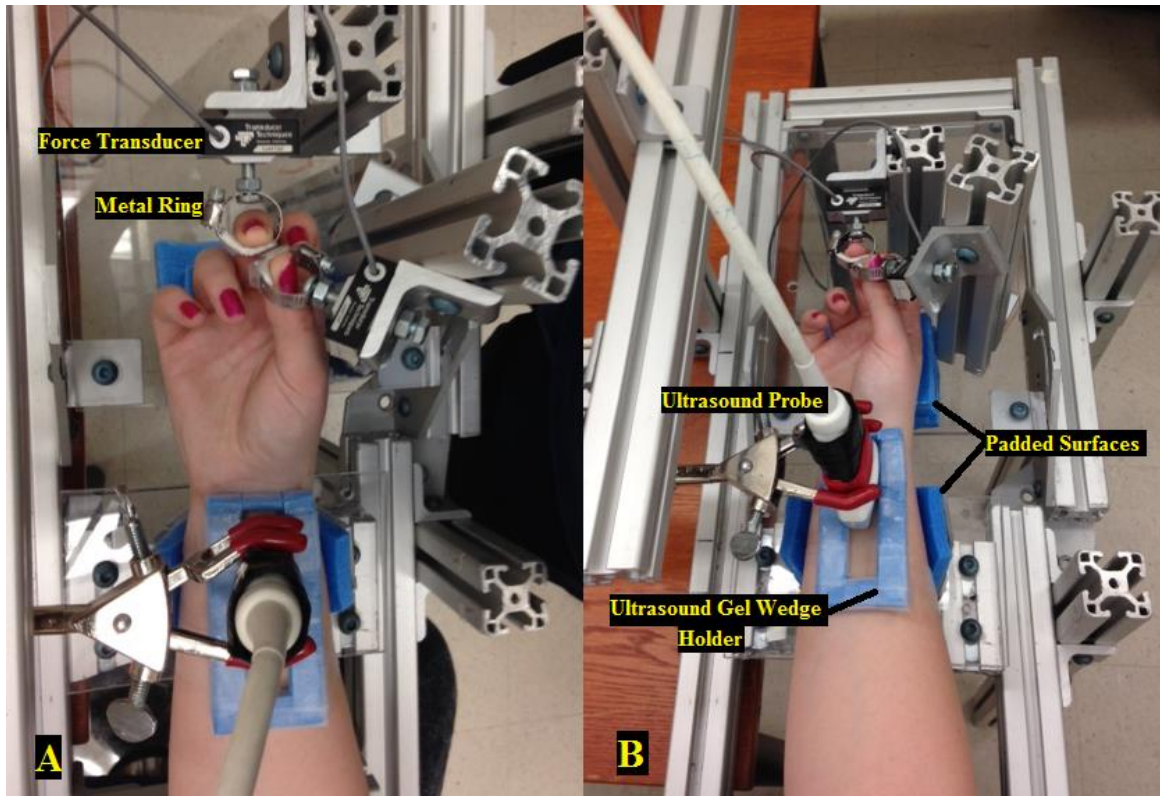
Setup for pinching trials. Aerial view of pinch posture (A). Oblique view of full fixture (B). A pinch grip was performed with the middle finger and thumb in rings attached to force transducers. The ultrasound probe is shown at the proximal wrist crease.
